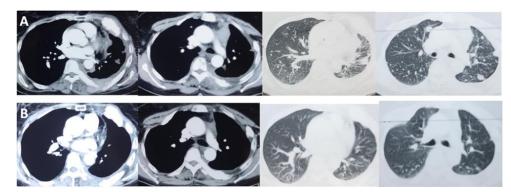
Comparison of chest CT scan with contrast before chemotherapy (A) and after 3 cycles of chemotherapy (B).
